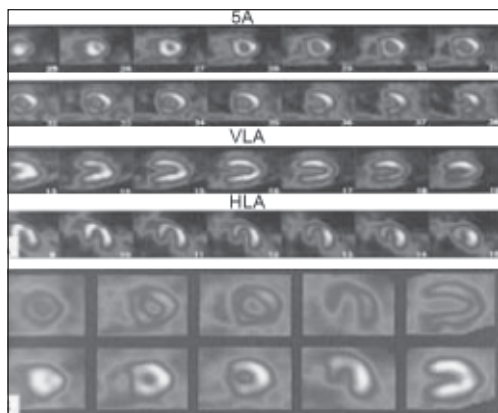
Normal gated SPECT image.
